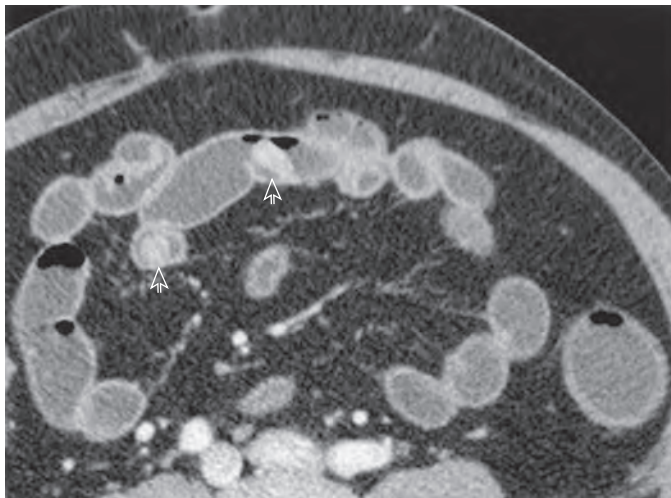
Peutz-Jeghers syndrome. CT enteroclysis performed with enteral water infusion and IV contrast enhancement shows multiple intraluminal polyps within the jejunum (arrows). The fluid density of the neutral enteral contrast medium is juxtaposed with the enhancing bowel wall, increasing the conspicuity of the tumor.
